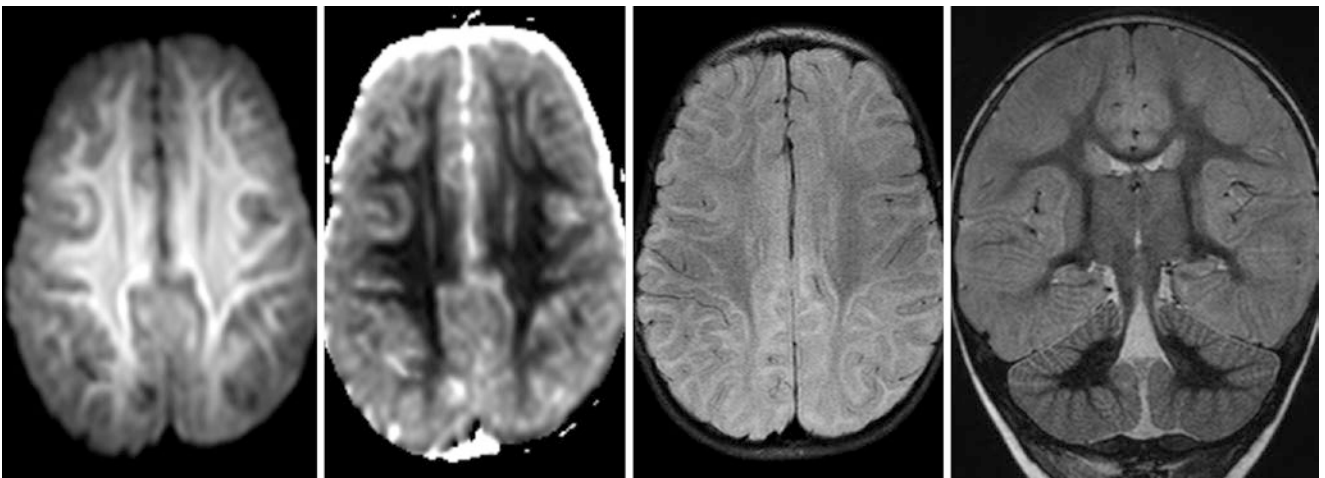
Comparison case of subacute HIE. A 3 T MRI in a 9-month-old infant with status epilepticus at 7 days postinsult showed confluent periventricular white matter abnormalities on DWI (*left*), ADC map (*left middle*), and FLAIR (*right middle*), along with diffuse cortical
